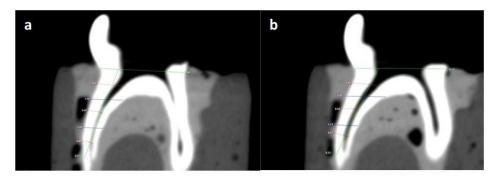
CBCT coronal images showing the maximum mesiodistal diameter measured at the center of each third (coronal, middle and apical) of distal canal before instrumentation (a) and after instrumentation (b).
